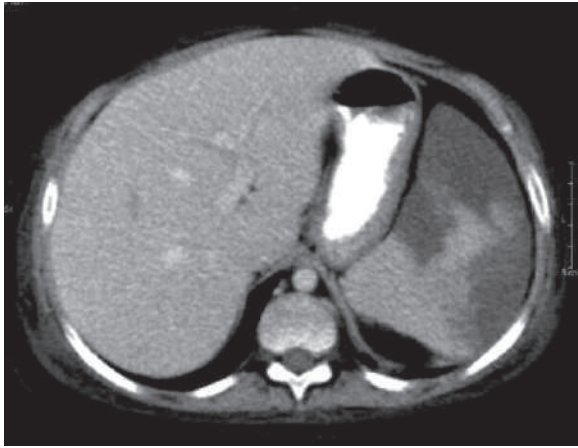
Axial abdominal postcontrast CT shows multiple hypodense wedge-shaped areas within the spleen, due to multiple areas of infarction
